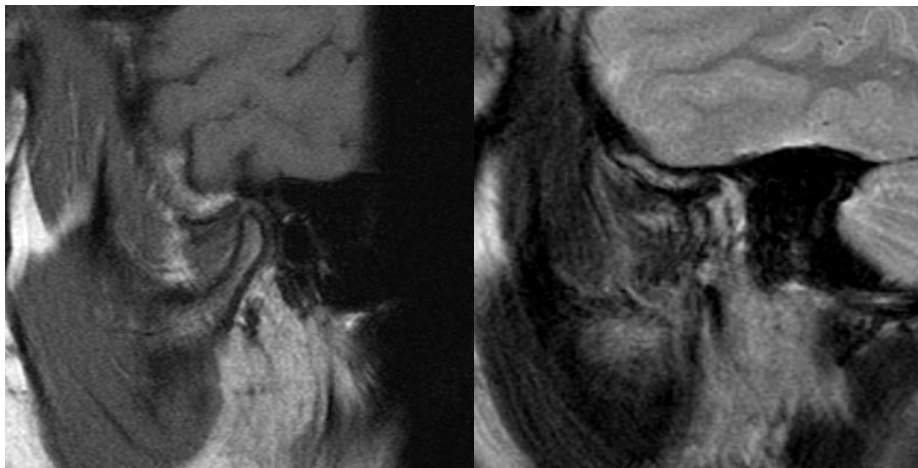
Pre-Treatment Sagittal T1 (a) and T2 (b) Weighted MRI of left TMJ in closed mouth position show a partial anterior disc displacement
